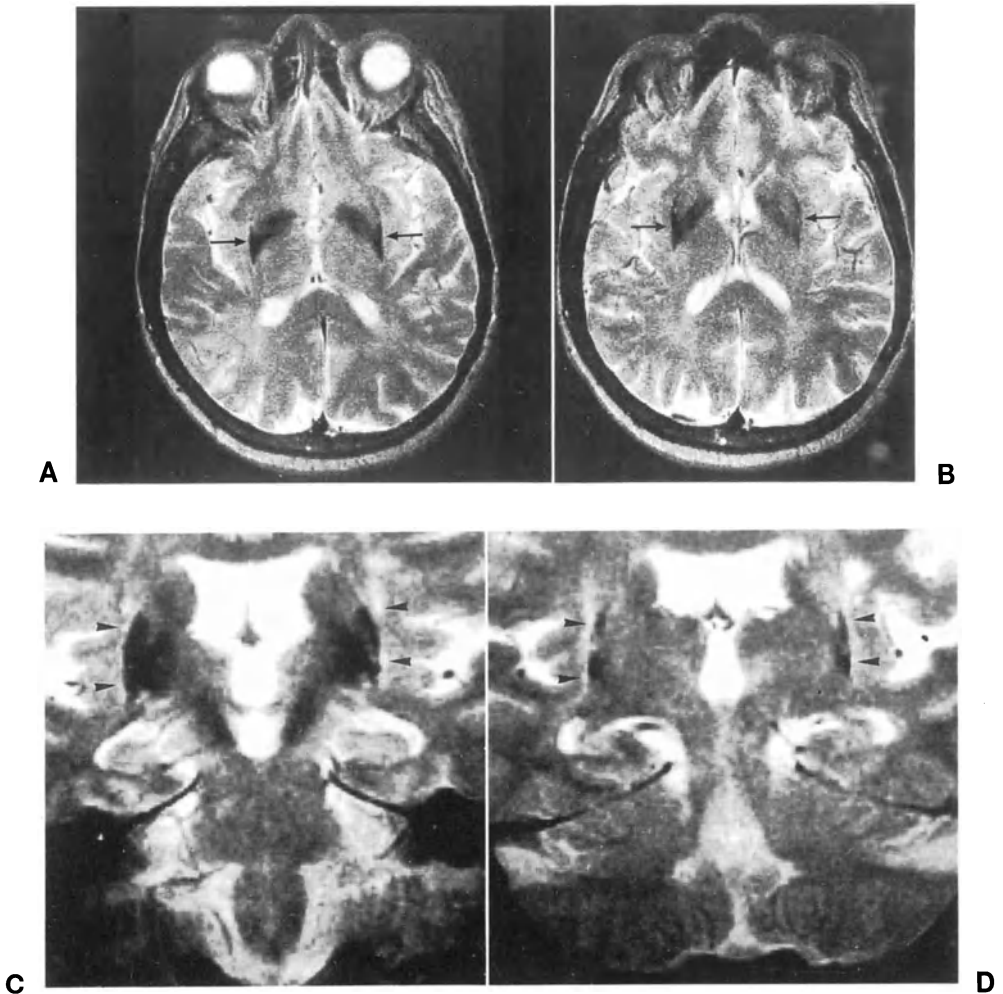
Multiple system atrophies. At 1.5T, involvement of the putamen is manifested by very low signal intensity in T2-weighted images. The loss of signal intensity of the putamen (arrows) prevails over that of the pallidum with reversal of the normal distribution (A and B axial sections; compare with Fig. 3C). This patient had severe involvement of extrapyramidal, autonomic and cerebellar systems and presented MRI abnormalities also in posterior fossa. Similar findings are present in a patient with diagnosis of Shy-Drager syndrome, who did not present clinical nor MRI findings of OPCA. Also note thin band of lateral hyperintensity (arrowheads; C and D coronal sections). [From J Comput Assist Tomogr (Savoirdo et al., 1989), with permission]
